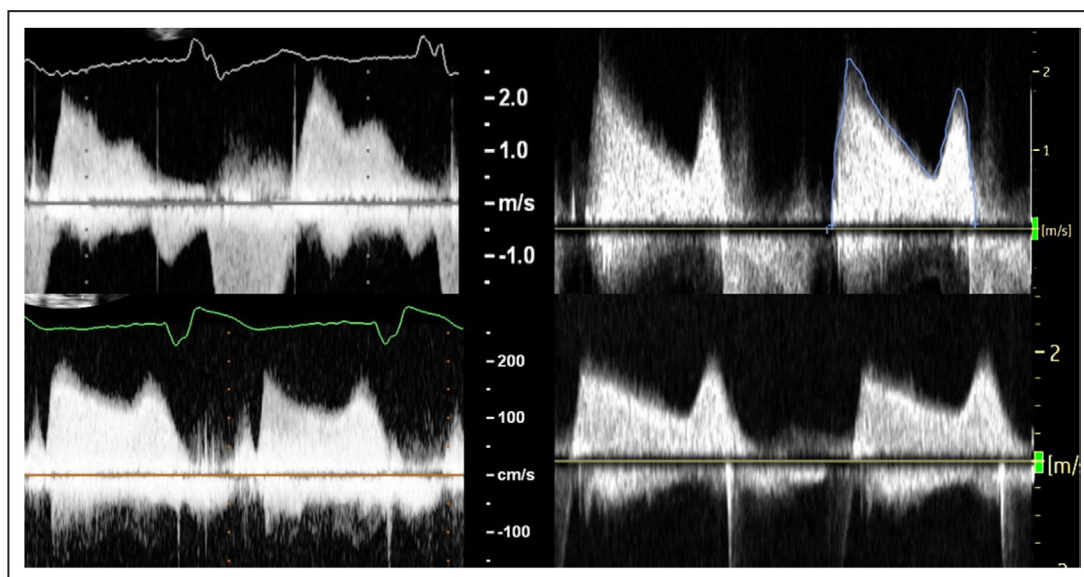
Comparison of continuous-wave Doppler signal in MAC versus RMS.
